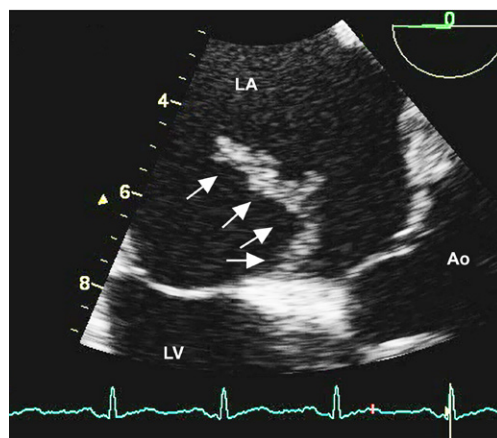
Transesophageal echocardiogram (midesophageal 4-chamber view, 0° rotation) shows a mobile, low-echoic restiform lesion at the left atrium (LA) (arrows) and a stalk attached to the left atrial septum near the foramen ovale.
